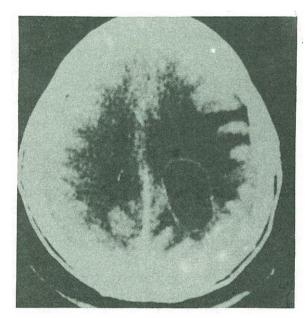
CT-scan showing cerebral abscess in a 32-year-old adult male patient with D-transposition of the great arteries and a large subaortic ventricular septal defect.
